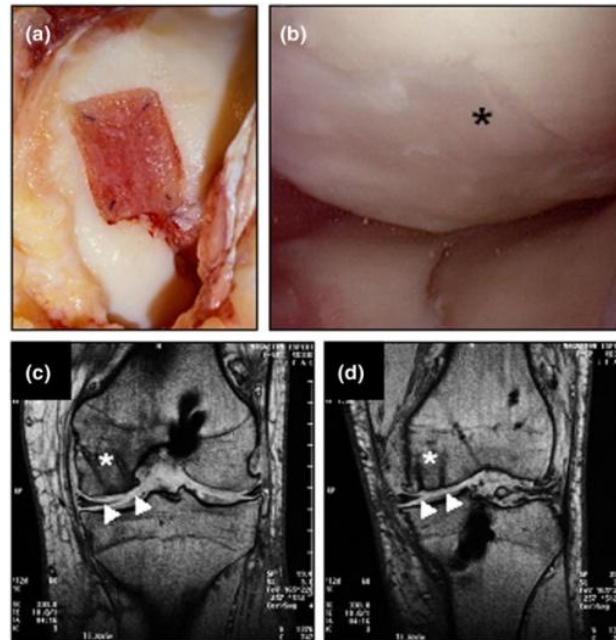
Arthroscopic and magnetic resonance imaging evaluation of cartilage defects treated with autologous chondrocyte grafts (BioSeed<sup>®</sup>-C). Situation of a cartilage defect situated at the femoral condyle covered with fixed scaffold (a). At 9 months after surgery, second-look arthroscopy showed the formation of a cartilage repair tissue of a tough condition (asterisk) (b). Magnetic resonance imaging (MRI) at 6 months (c) and 12 months (d) after implantation shows. The repair tissue covers the defect (white triangles) and gives a slightly altered MRI signal [143].
